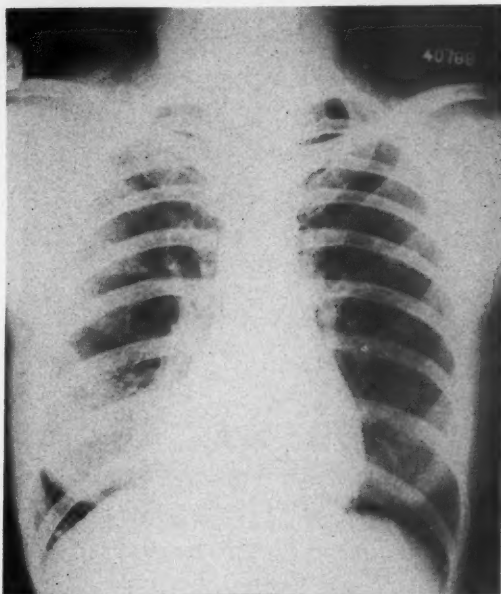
Roentgenogram taken January 1950, showing right basal pneumonitis
